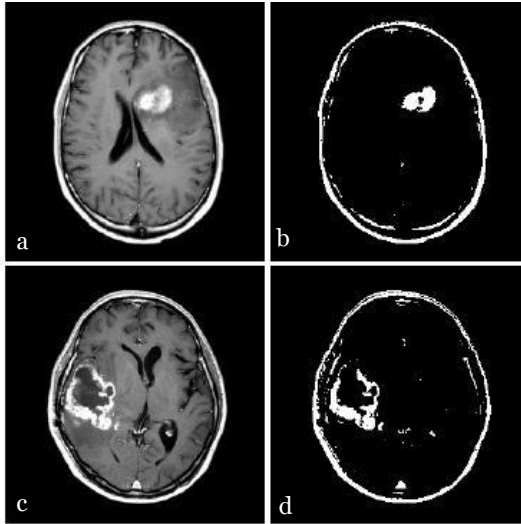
Segmentation by Global thresholding (a,c) T1-weighted post-contrast image, (b,d) image after intensity thresholding. The binary segmentation fails in locations of bone and fat (false positives).
